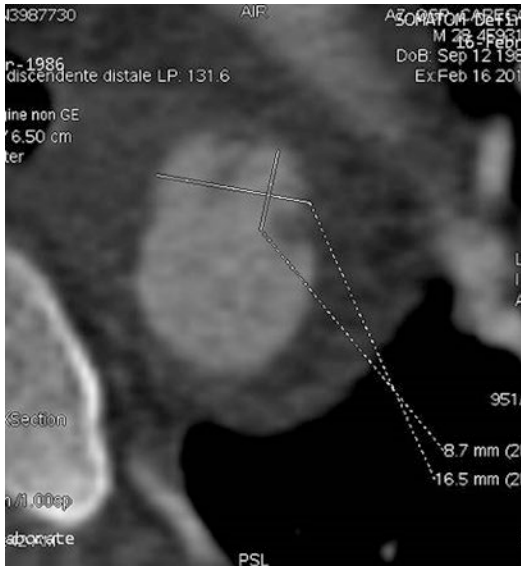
Axial CT scan shows pseudoaneurysm: irregular outlines and surrounding hematoma
